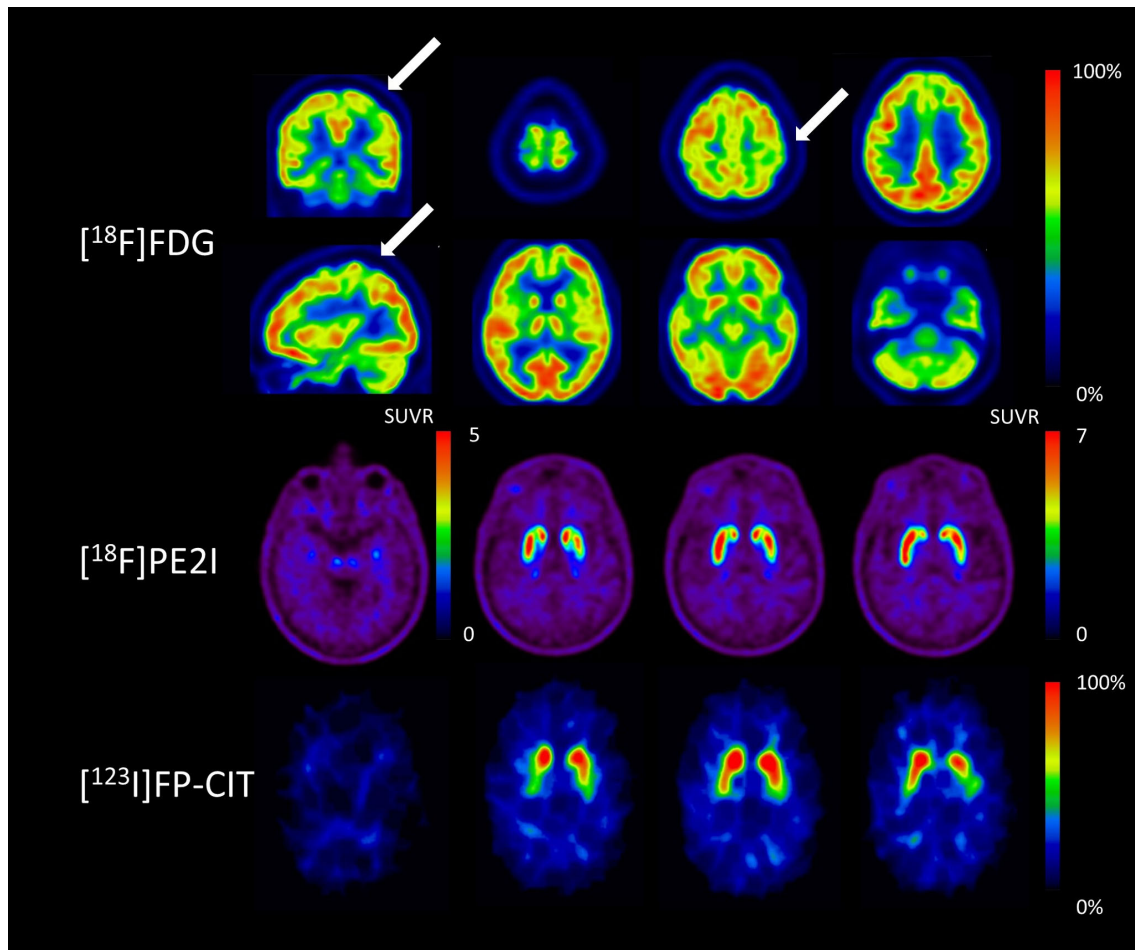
Orthogonal ^{18}F -FDG PET slices showing a mild hypometabolism in the left sensorimotor cortex corresponding to the right arm location of the cortical homunculus. Middle and bottom row: transverse slices of dopamine transporter imaging. Both classical ^{123}I -FP-CIT SPECT and high resolution, selective ^{18}F -PE2I PET showed a normal presynaptic dopaminergic uptake. Images are in radiological orientation.
